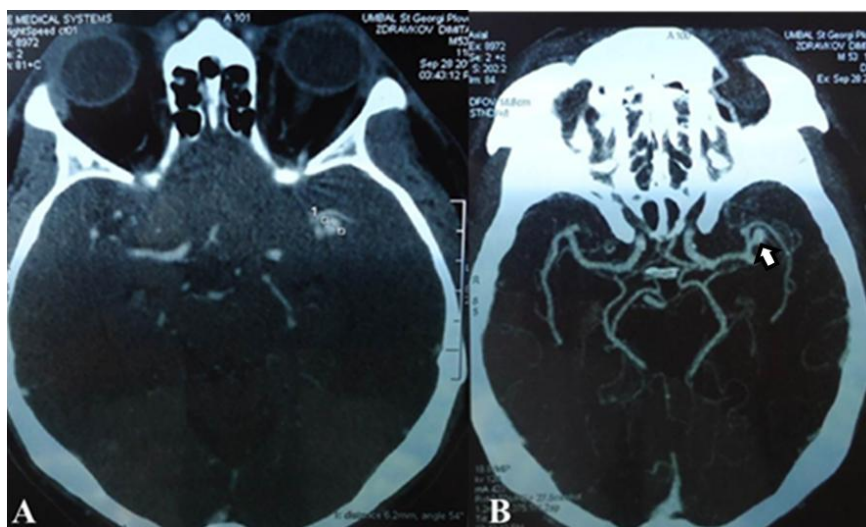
A/ CT image of small spontaneous temporal hematoma; B/ CT angiography shows an aneurysm of the middle cerebral artery
